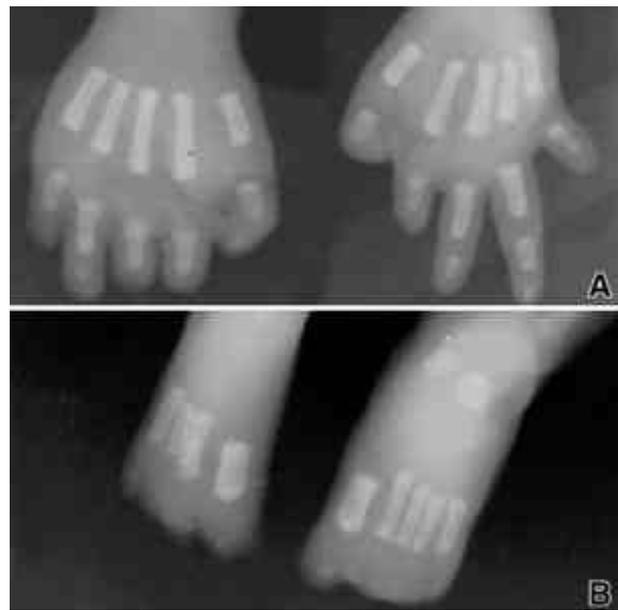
Postmortem X-ray. Right hand shows defects of middle and terminal phalanges of 2nd, 3rd & 5th fingers and terminal phalanx of 4th finger. Left hand shows absence of middle and terminal phalanges of 2nd & 5th fingers and terminal phalanx of 3rd finger (A). Rudimentary toes-bones are seen (B).
